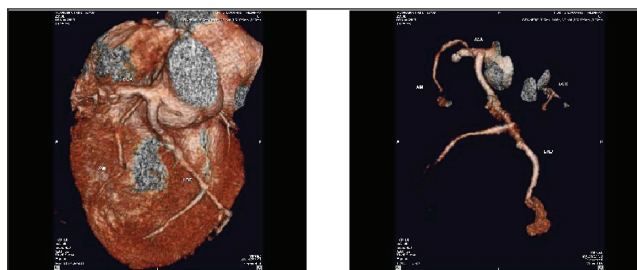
Computed tomography coronary angiography: Common ostium for right coronary artery (RCA) and left anterior descending artery; absent left main artery. Left circumflex artery short in length and significantly narrow in caliber; completely blocked RCA in proximal segment due to dense calcification
